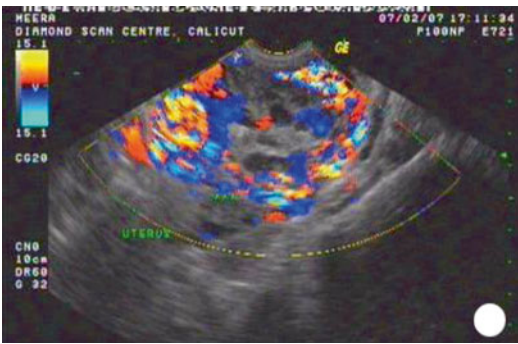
Color Doppler study showing highly vascularized area in the myometrium in invasive mole
